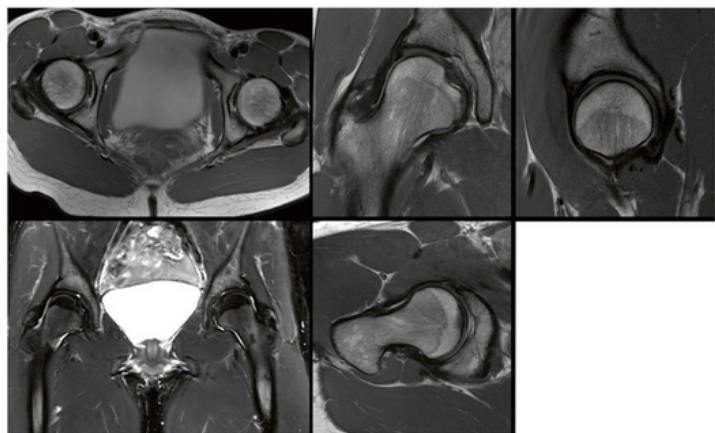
Example MR images of all five sequences obtained utilizing the method described.
